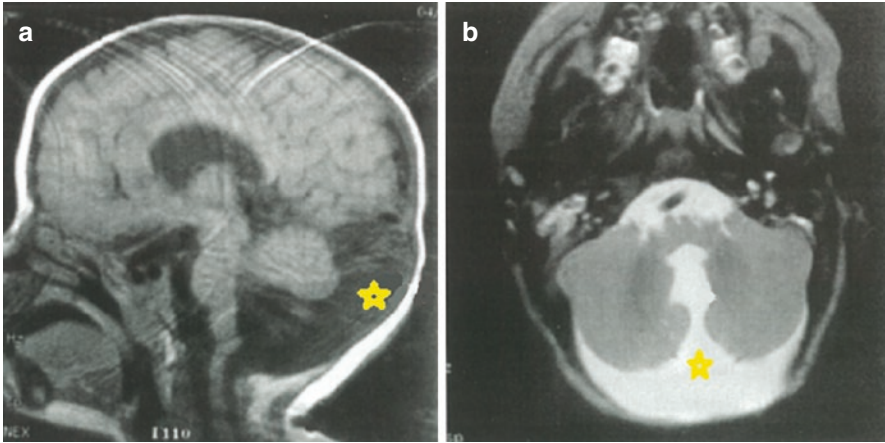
(a) T1-weighted midsagittal magnetic images of Dandy-Walker malformation (yellow asterisks) in the posterior fossa, displacing the cerebellum superiorly; (b) T2-weighted axial views of the cystic lesion contiguous with the fourth ventricle
